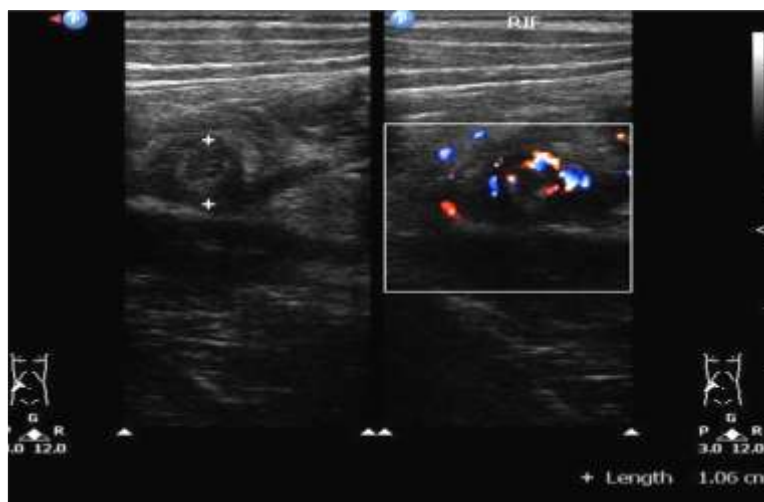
Suppurative appendicitis - aperistaltic, noncompressible, blind-ended, tubular structure with laminated continuous wall arising from base of cecum. Appendicitis is characterised by a wall thickness > 2 mm & diameter > 6 mm. On Color Doppler study there is increased vascularity in appendiceal wall.
